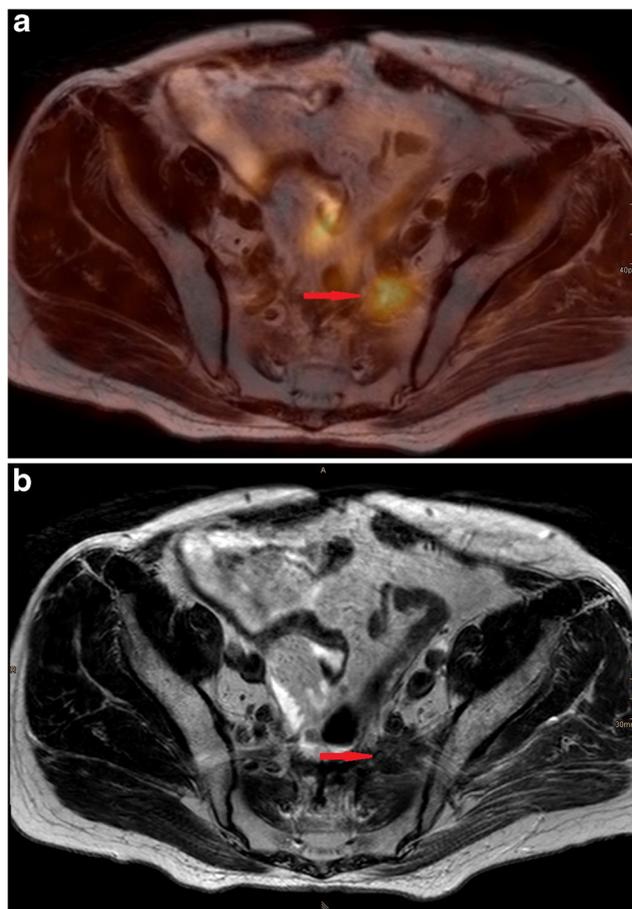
a Axial PET/MRI fusion image demonstrating a lesion with FDG uptake in the course of a sacral nerve. b Axial T2-weighted image showing diffuse hypointense changes in the left presacral region
